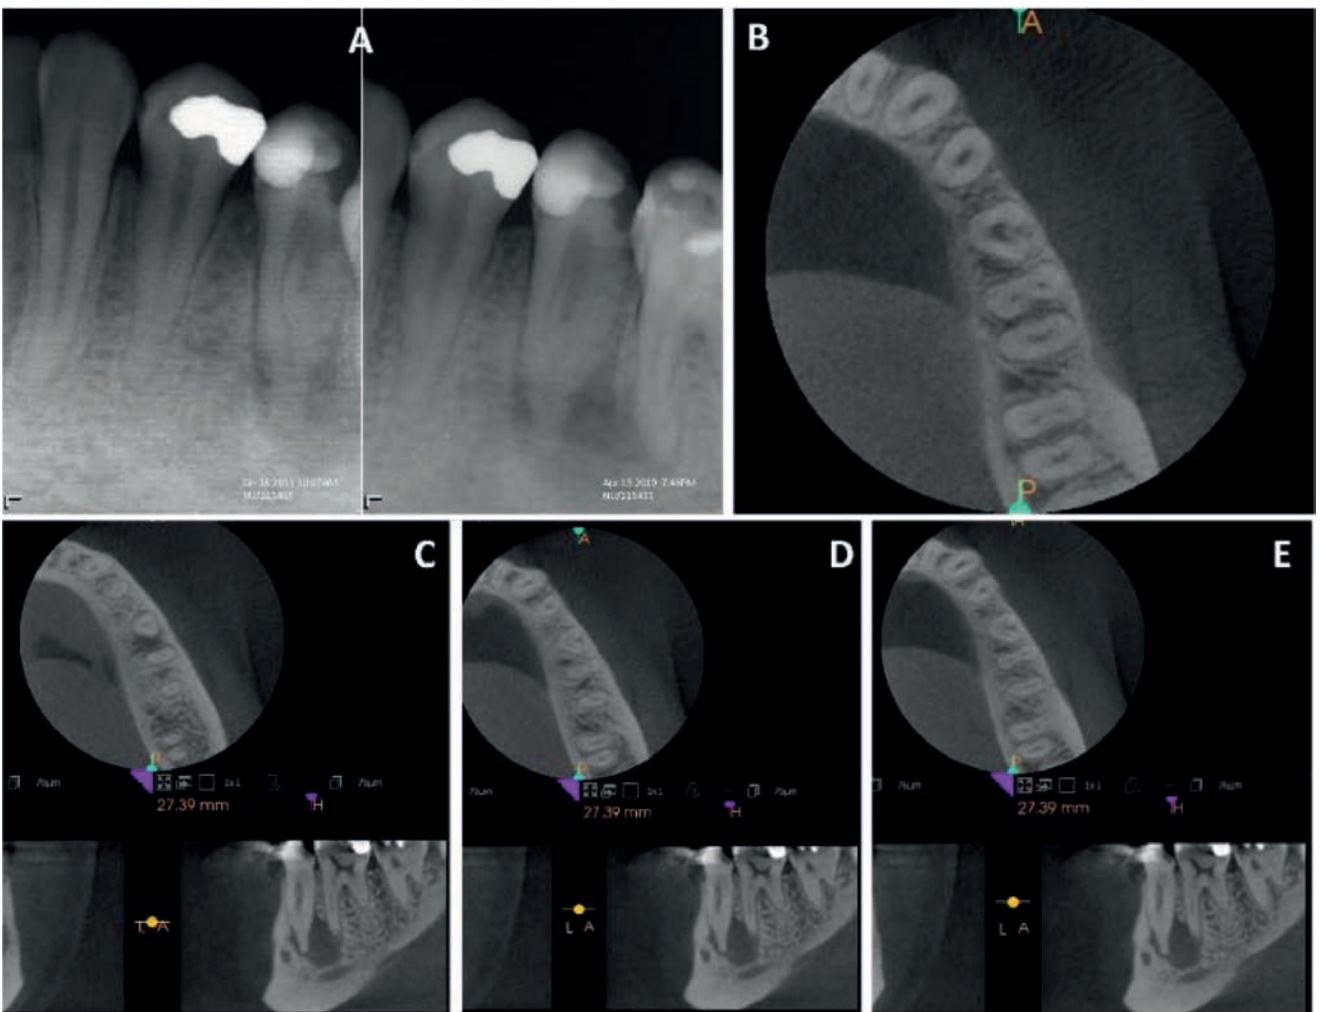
Preoperative radiographic assessment, apical lesion associated with 35# (A), CBCT scans reveal C-shaped canal on coronal third with buccal groove (B), three canals in the middle third along with apical lesion (C and D), one apical foramen at end of canal (E)
